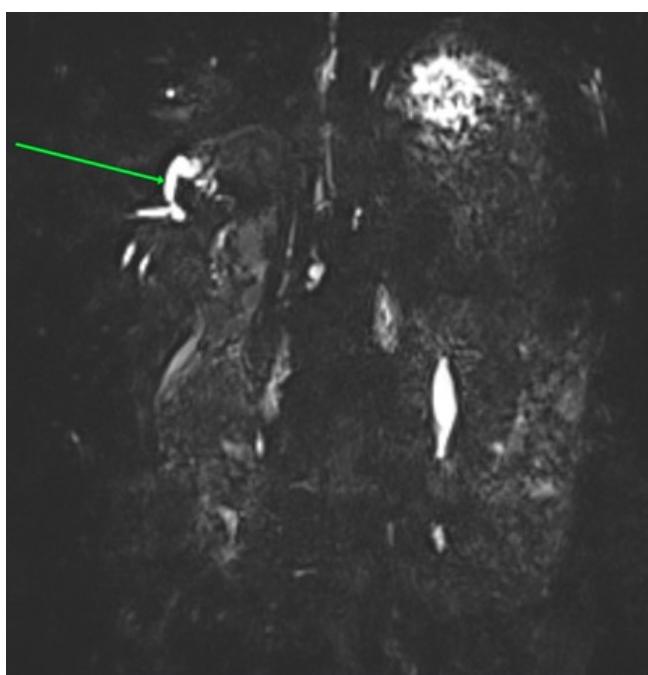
Coronal section of the 3D BILI sequence on MRI, showing the persistence of a discreet ectasia of the proximal intrahepatic bile ducts
